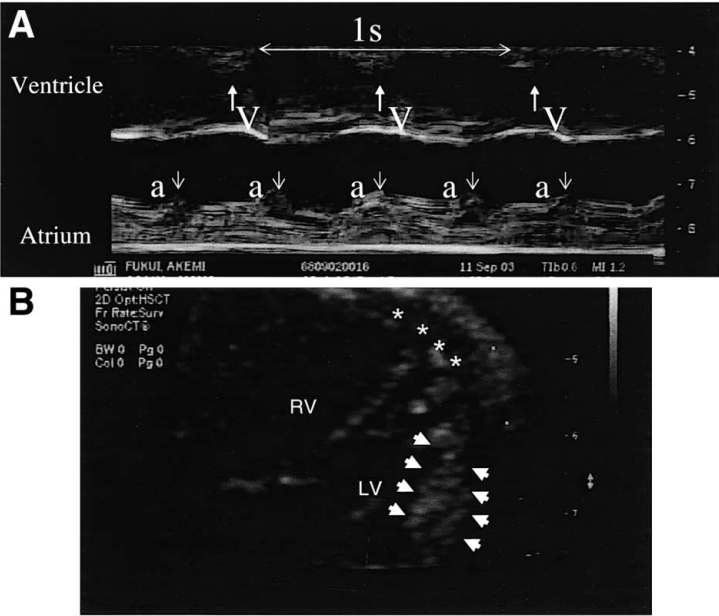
(A) Fetal echocardiography by M mode method shows complete atrioventricular block at 25 weeks gestational age. a, atrial wall motion; V, ventricular wall motion. (B) Fetal echocardiography at 27-weeks gestational age shows thick pericardium (arrow) and thin myocardium at the apex (asterisk). The myocardium is a loose interwoven meshwork of muscle fibers that are supplied directly with blood via the large surface area of the numerous intertrabecular spaces (arrowheads). LV, left ventricular; RV, right ventricular.
